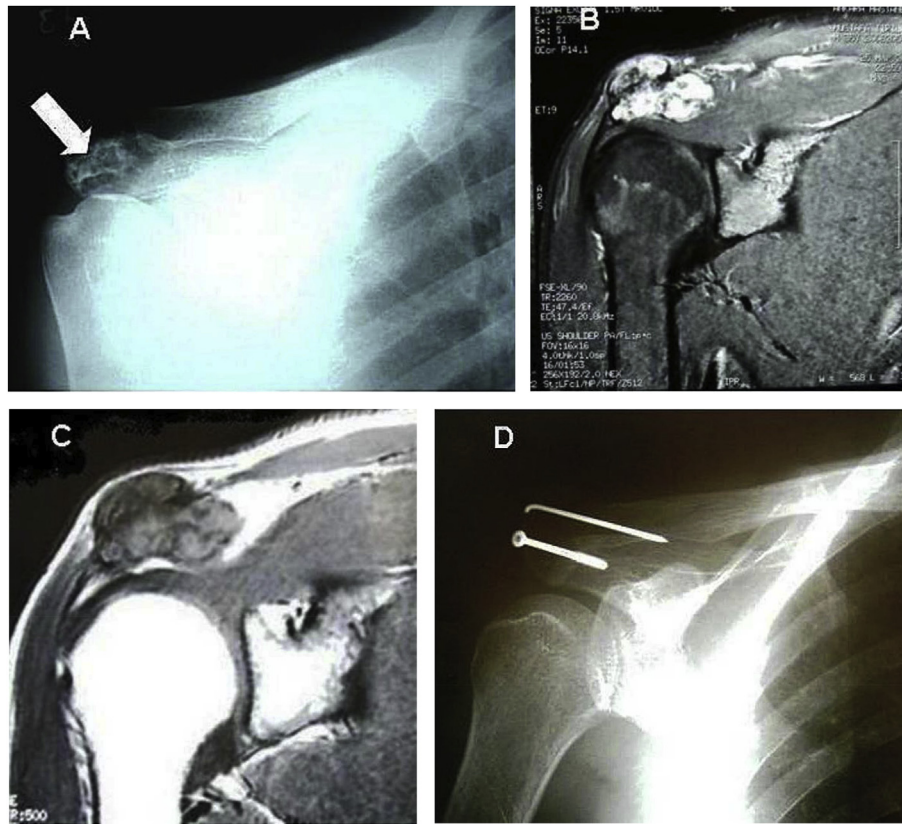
A: Anterior-posterior image showing an expansile and septated bone lesion on the right acromion, no evidence of bone destruction is noted. B: T1-weighted coronal MRI revealing an isointense, expansile bone lesion, having a large soft tissue component in the superior-lateral position of the right acromion. C: T2-weighted coronal image revealing a hyperintense and lobulated bone lesion. D: An image showing the fixation of the autogenous iliac bone graft, with a K-wire, to the clavicle, and a partially threaded spongiosa screw toward neck of coracoid process.
